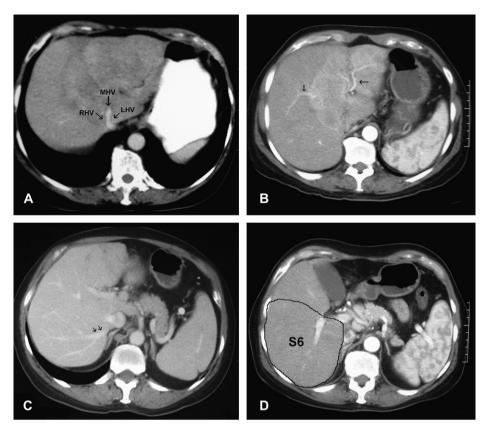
Preoperative computed tomography scan (A) involvement of all three major hepatic veins, (B) involvement of left and right anterior pedicles (arrows), (C) stout inferior right hepatic vein is present (arrows) and (D) segment 6 is hypertrophied and comprises 38% of total liver volume. RHV – right hepatic vein; MHV – middle hepatic vein; and LHV – left hepatic vein.
